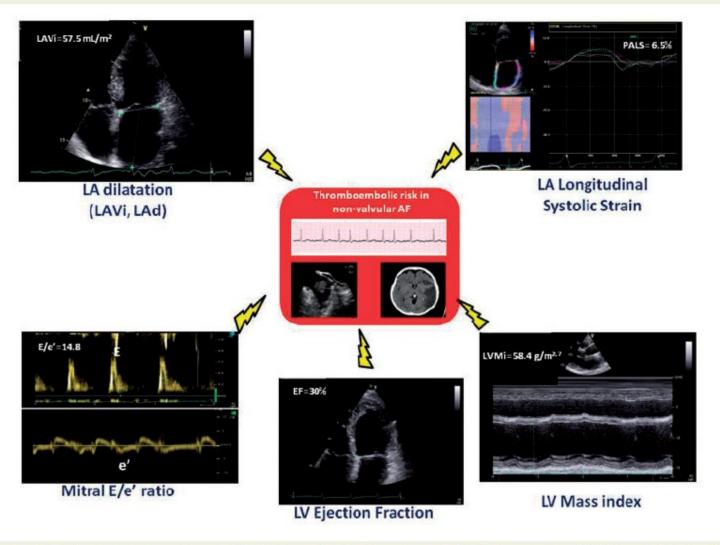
Figure I Key echo-Doppler parameters of potential additive value for thromboembolic risk prediction. LA, left atrial; LAd, left atrial diameter; LAVi, left atrial volume index; LV, left ventricular.
